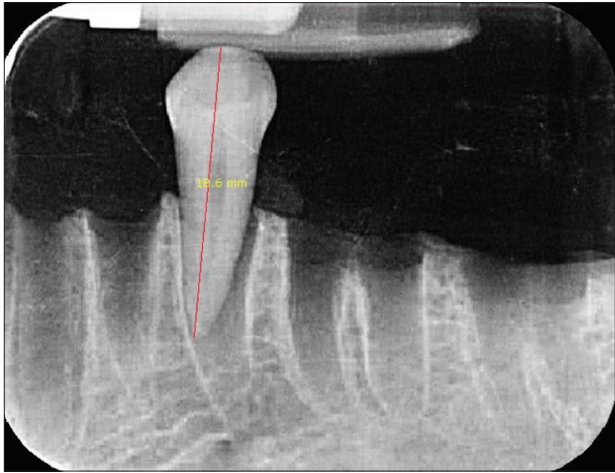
Measurement by intraoral periapical radiograph
